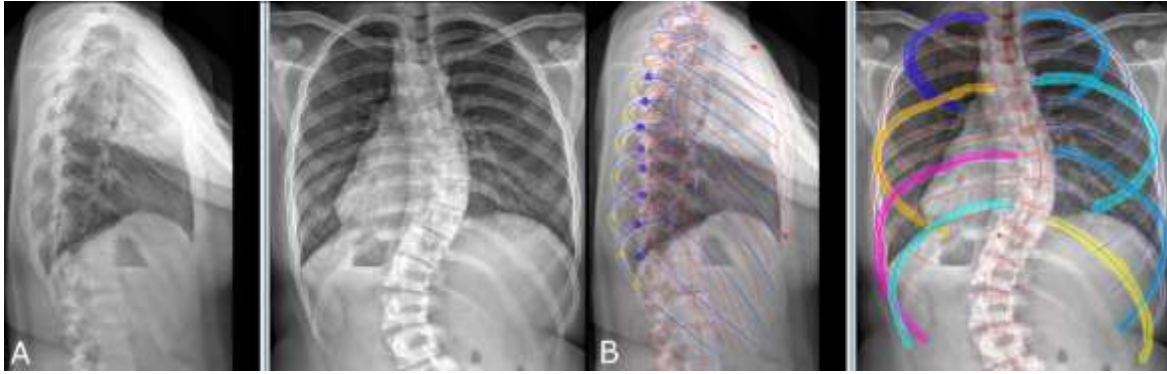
(A) Original lateral and frontal x-rays and (B) rib cage 3D model fitted on painted identification
